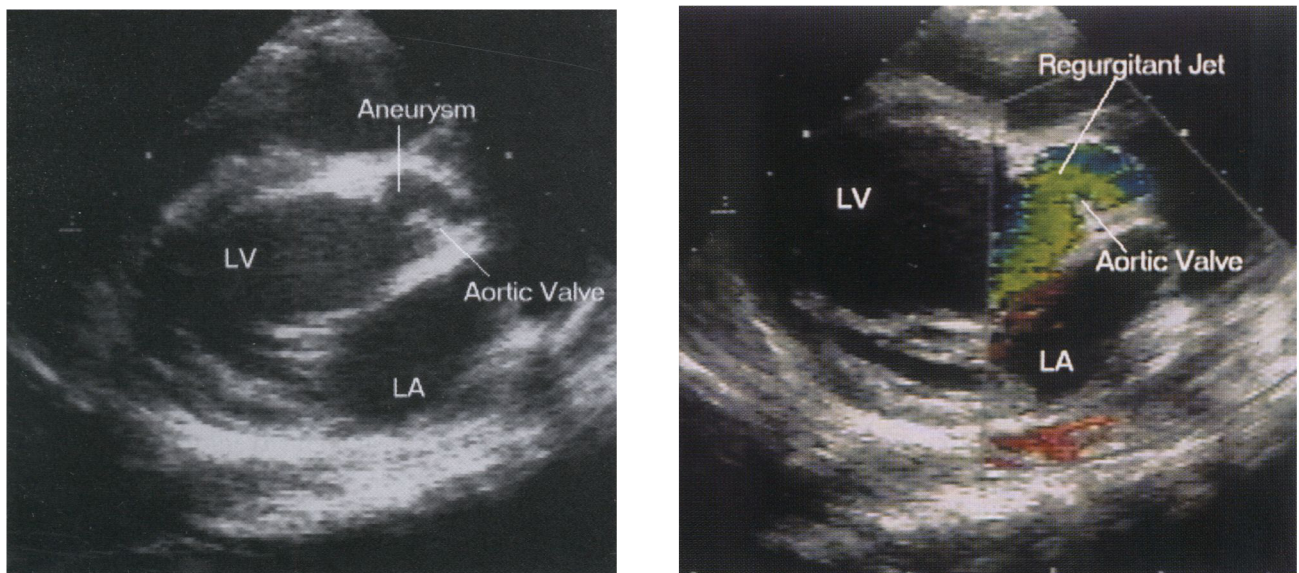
a). Parasternal long-axis; b). parasternal long-axis (colour Doppler). LA: left atrium; LV: left ventricle.
